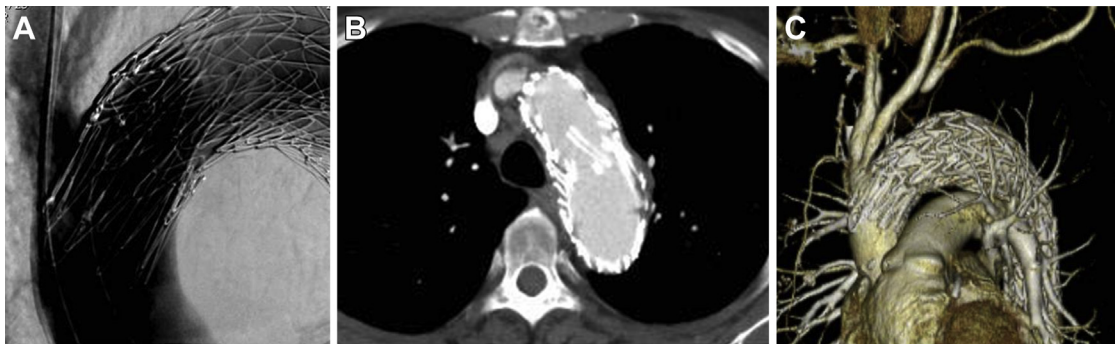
A, Aortography performed after fenestrated stent grafting. B, Follow-up computed tomography performed at 7 months showed complete thrombosis of the sac. C, Three-dimensional (3D) computed tomography reconstruction image 7 months after thoracic endovascular aortic repair (TEVAR).
